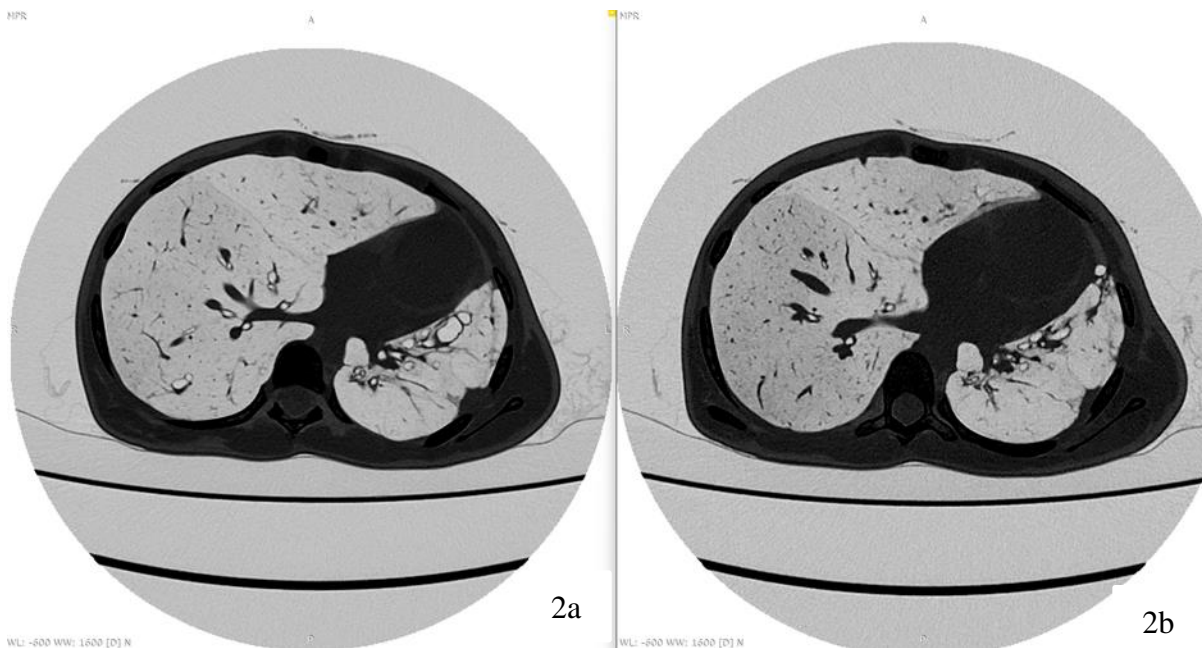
Figure 2a: Axial images of expiratory chest CT, lung window showing bronchiectasis involving bilateral lungs, more in left lower lobe with principal involvement of segmental and subsegmental bronchi. Volume loss of left lung and ipsilateral shift of mediastinum
